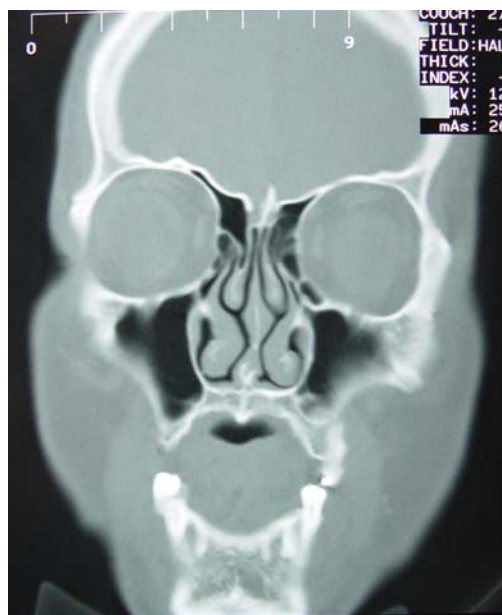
CT scan of a normal nasal cavity and sinuses without contact point.
